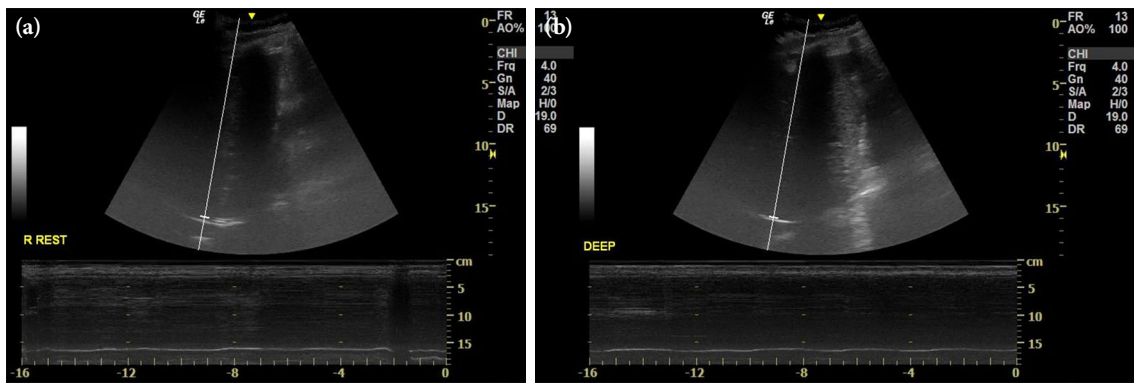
M-mode ultrasonography showing right hemidiaphragm paralysis during tidal volume (a) and deep (b) breathing after reintubation.
